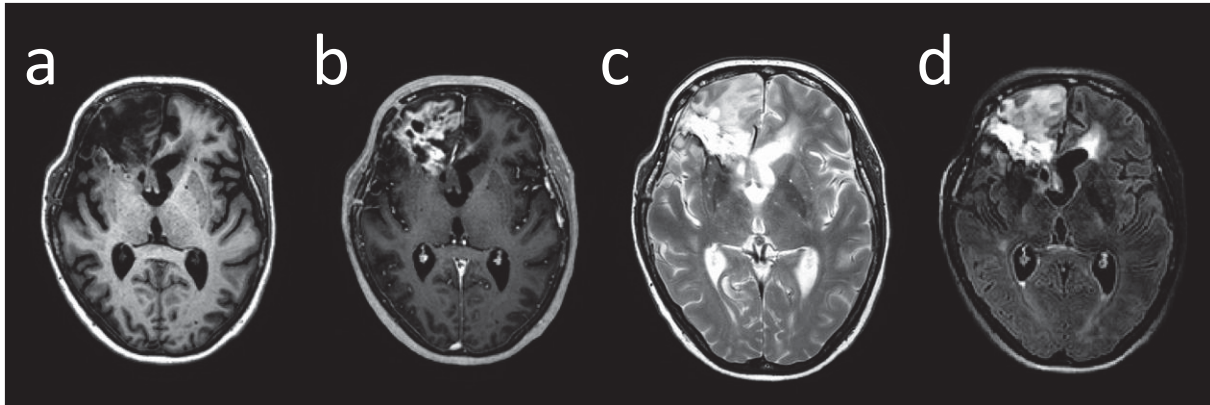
Structural MRI of a GBM in the right frontal lobe. T1w images before (a) and after (b) the administration of a gadolinium based contrast agent (GBCA) are shown on the left side. T2w image (c) and Fluid Attenuated Inversion Recovery (FLAIR) image (d) to the right. Note how the tumor appears dark on the T1w image before contrast (a) and the heterogeneous enhancement pattern after GBCA administration with a mix of enhancing and non-enhancing regions (b). Periventricular high intensity lesions are easier recognized in the FLAIR image compared to T2w image due to suppression of the T2w high intensity cerebrospinal fluid signal.
